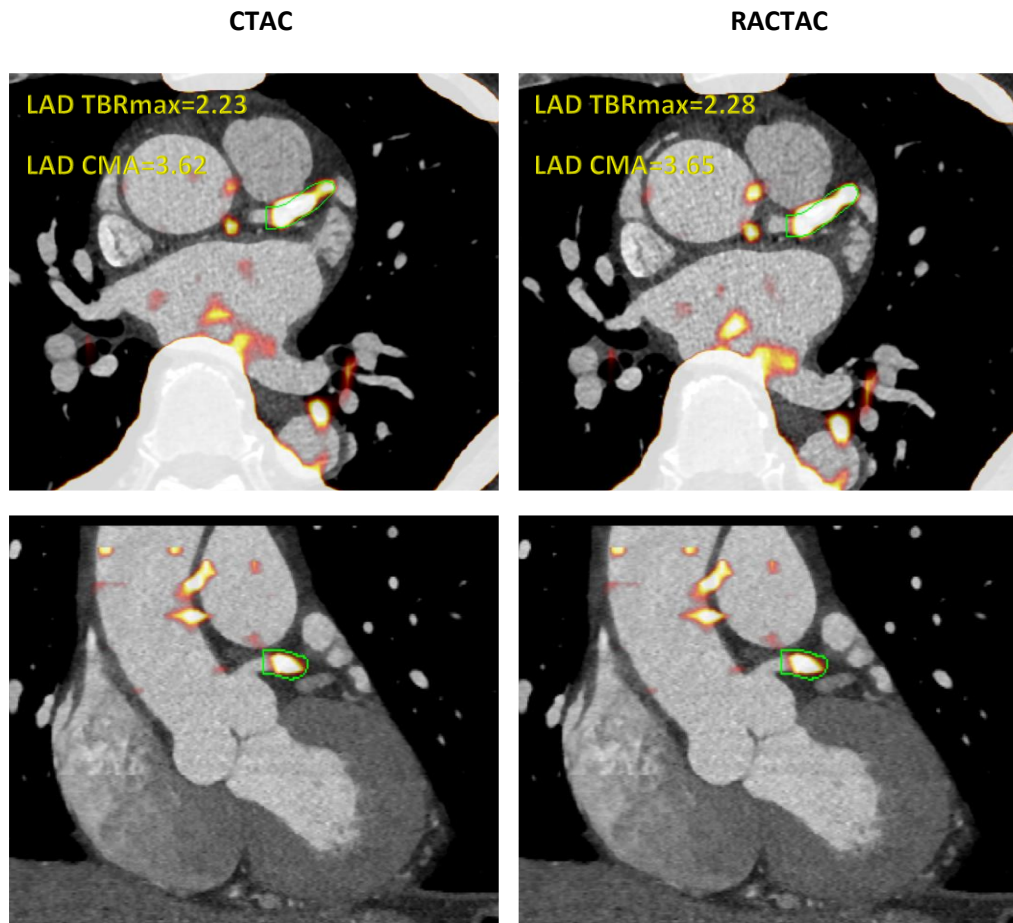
Left anterior descending artery ^{18}F -NaF uptake. Left panel shows fused CTA and PET images reconstructed using the CTAC maps, whereas shows the same CTA fused with PET an image reconstructed using RACTAC. There is good agreement between the measurements.
